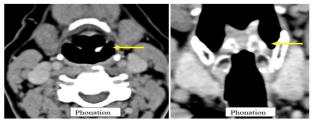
Non phonation CT shows apparent thickening of the left pyriform sinus but with adequate distension on "EE" phonation, involvement was ruled out
